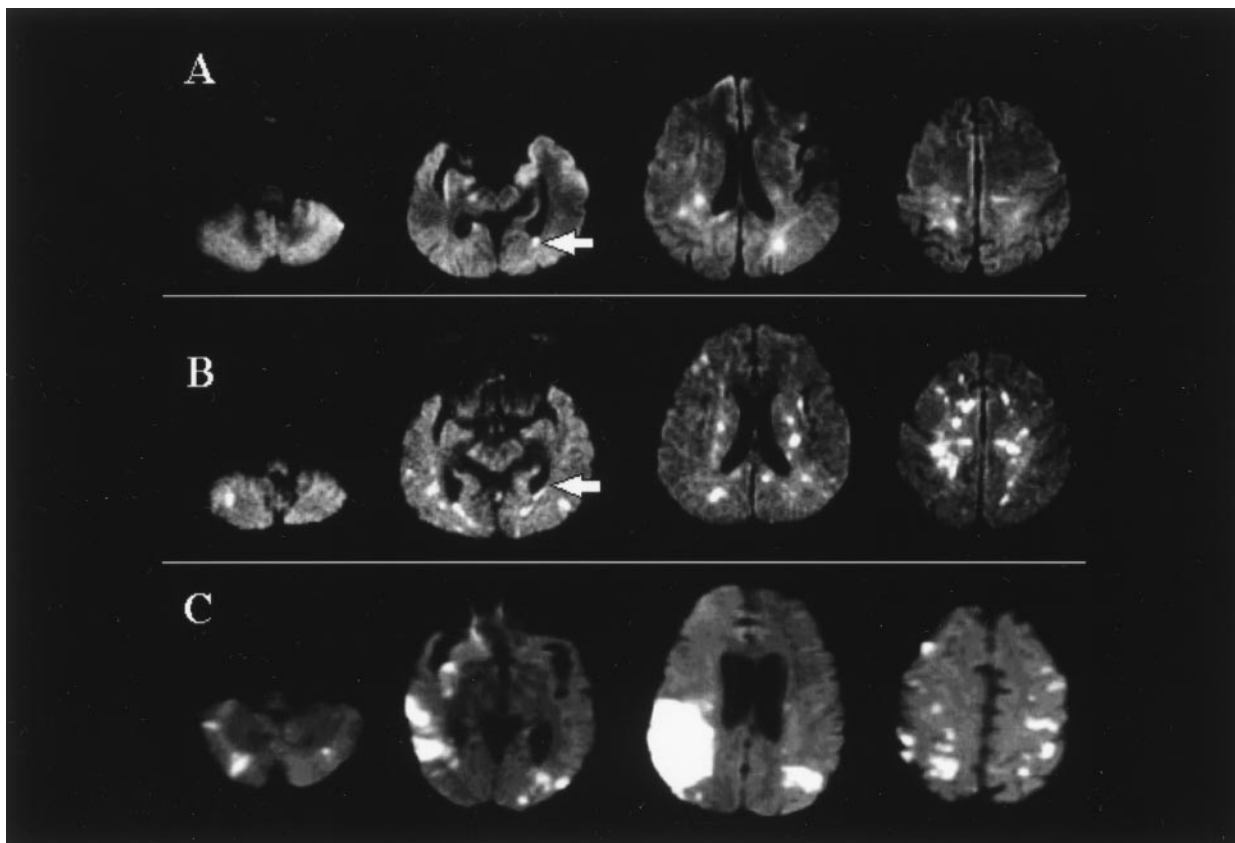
A, Initial DWI in a patient with infective endocarditis shows disseminated punctate ischemic lesions (pattern 3). Note the incidental ventricular hyperintensity (arrow), suggestive of ventriculitis. B, Follow-up DWI after 1 week shows additional punctate lesions but no change in the stroke pattern. C, Initial DWI in a patient with nonbacterial thrombotic endocarditis shows multiple small and large lesions (pattern 4).
